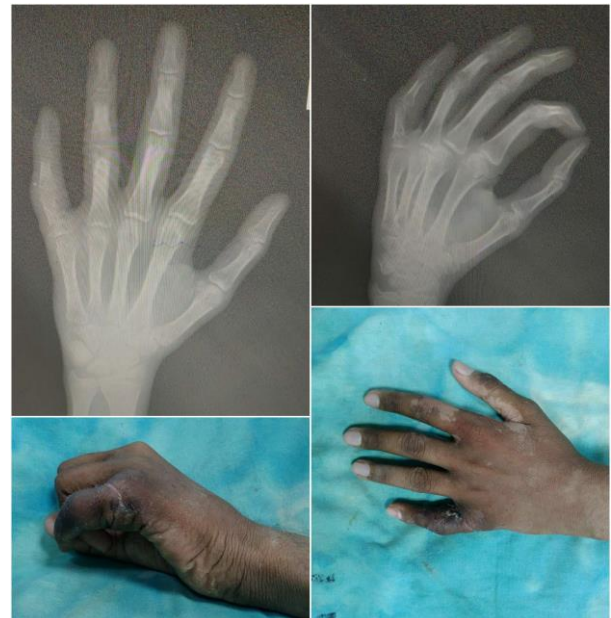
Pre-operative clinical pictures, X-rays and 3D CT showing sinus tract from proximal phalanx of left little finger.
